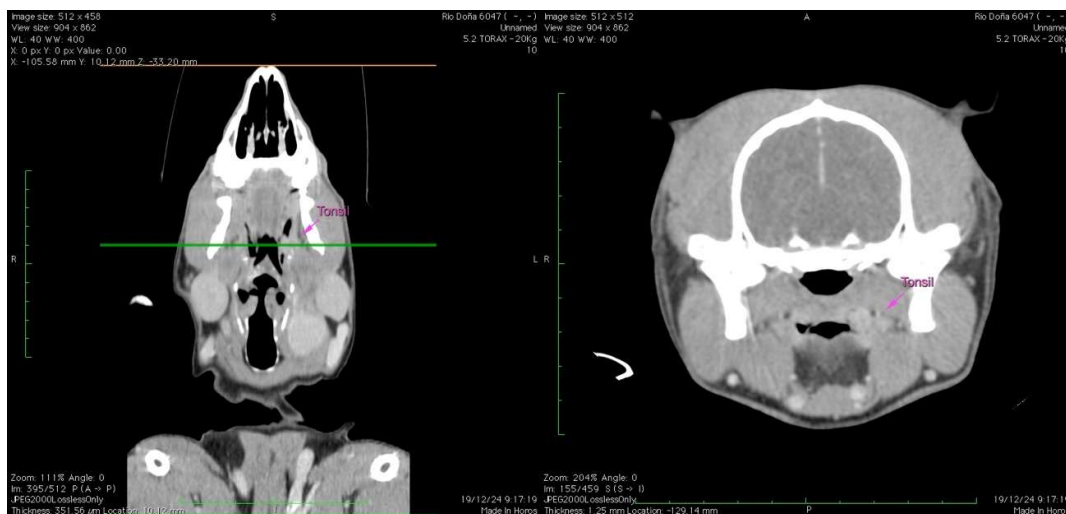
Head computed tomography (CT) images of the patient. Left: coronal view. Right: transverse view. The right tonsil is indicated in both views (pink arrows), which appears mildly enlarged.
